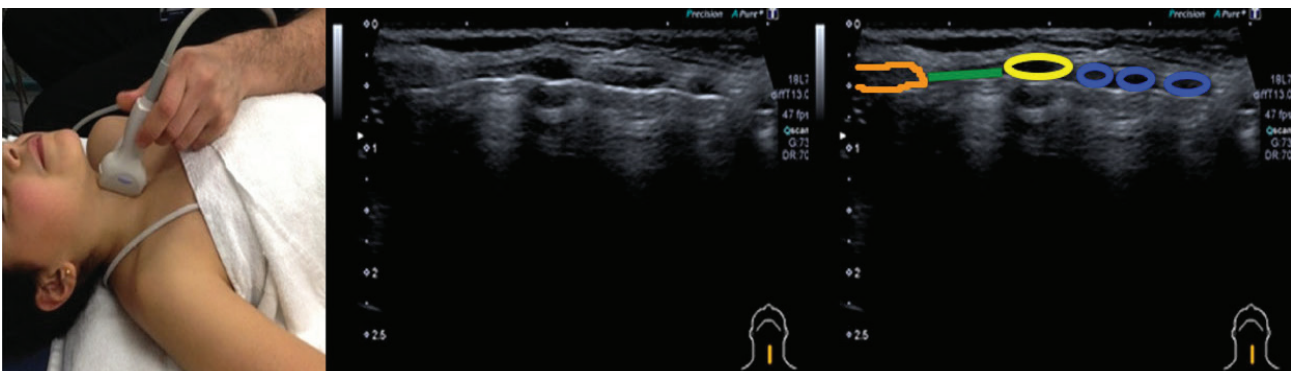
Ultrasound of the longitudinal view of the trachea
